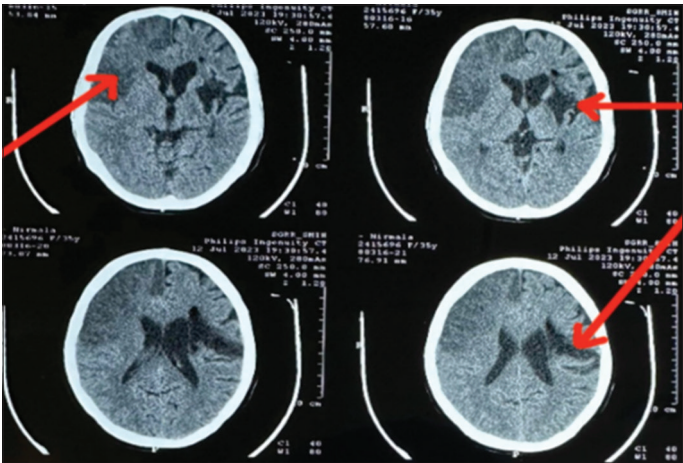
Axial computed tomography brain images showing (right): Wedge-shaped hypodense area in the right frontal lobe indicating acute/subacute infarction; (left): Encephalomalacic changes in the left frontal region consistent with chronic ischemic injury and gliosis
